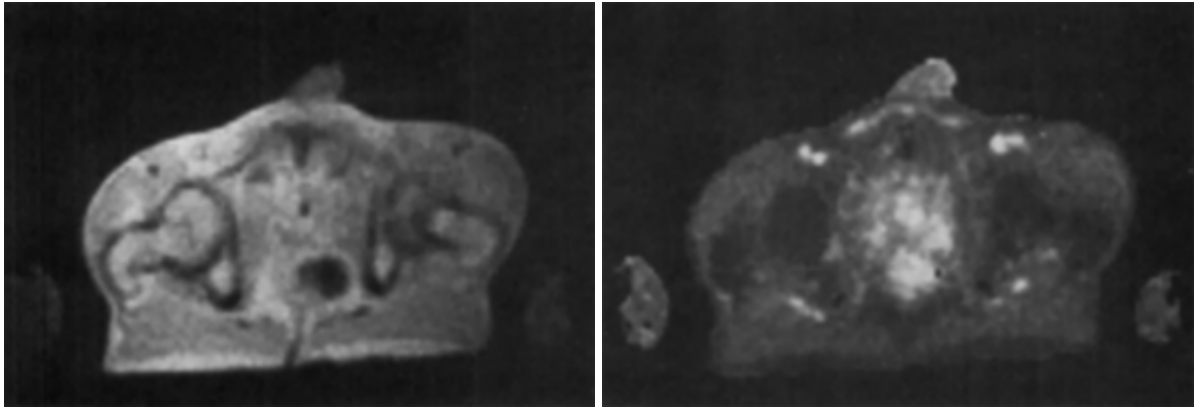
PDW imaging of Ca prostate and T1W MRI image of Ca prostate
